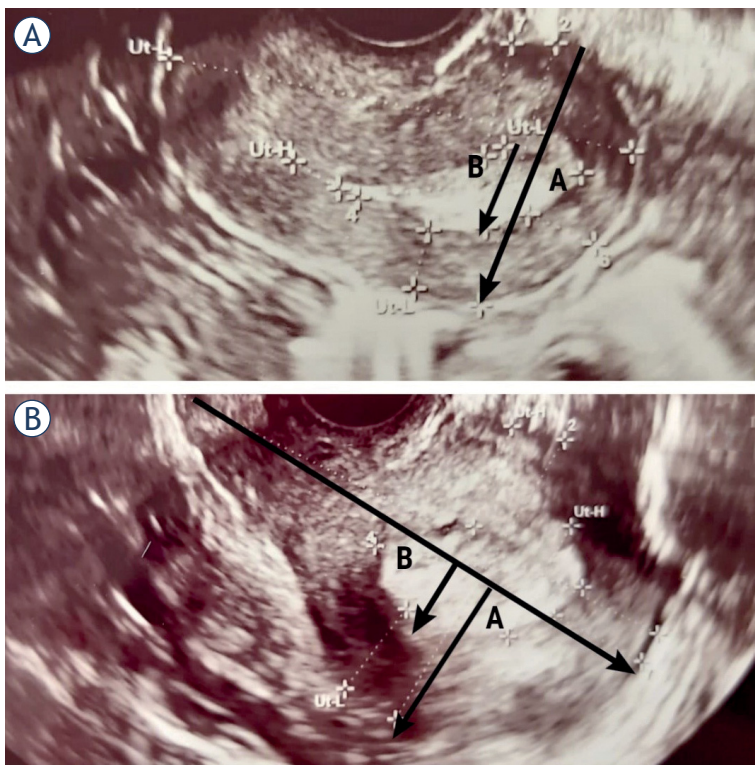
Assessment of myometrial invasion in patients with transvaginal ultrasonography (TVUS). Stage IA endometrial cancer in a 61-year-old postmenopausal woman, correctly diagnosed by TVUS and MRI. Karlsson's method indicating infiltration of superficial muscle (29%) (A). Stage IA endometrial cancer in a 53-year-old postmenopausal woman. Gordon's method indicating infiltration of superficial muscle (35%) (B).
